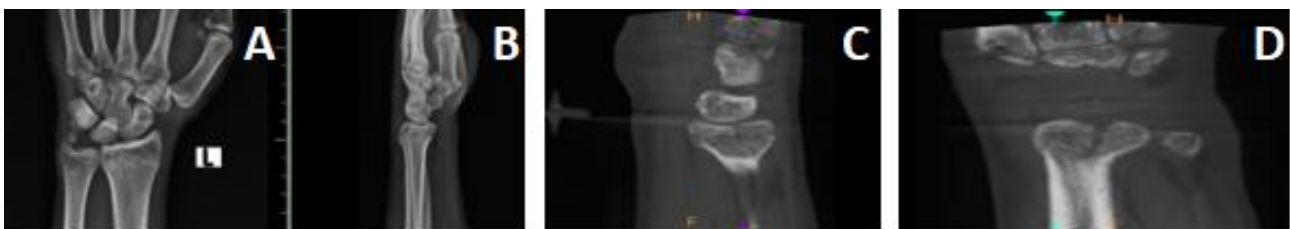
Distal radius comminuted fracture. General radiographs (A,B) reveal only one linear fracture, whereas CBCT images (C,D) clearly demonstrate multiple hidden fractures.
